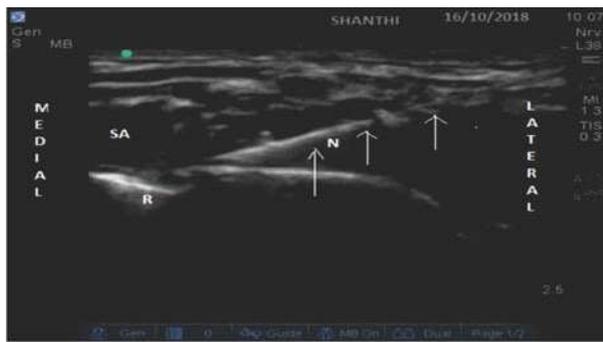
Transverse sonogram of the needle (arrows) with the needle tip in the corner pocket N-Needle, R-First Rib, SA-Subclavian Artery.
